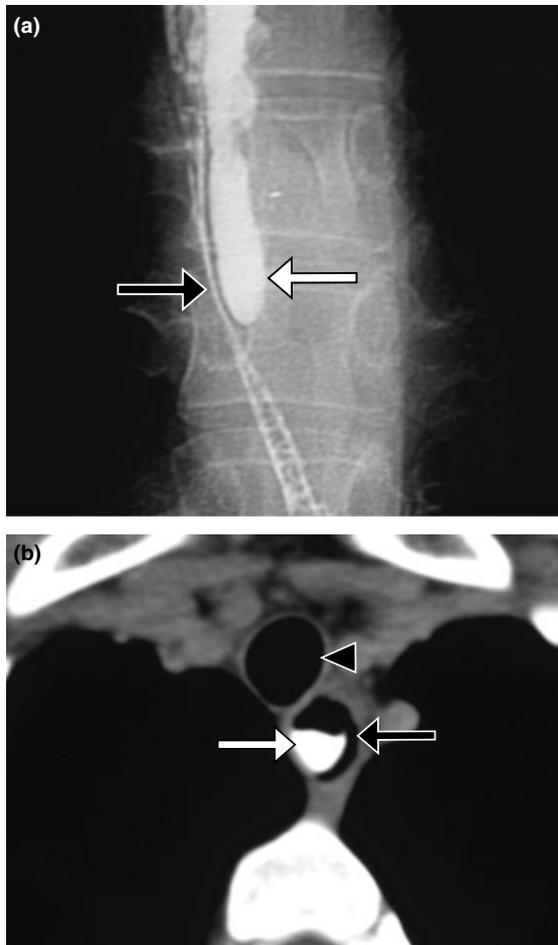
(a) Oesophagography from a 35-year-old female patient, suffering from dysphagia for 15 years. This radiograph was performed immediately after an attempt to remove an impacted food bolus by rigid oesophagoscopy and shows a long dissection of the oesophageal wall. Laceration, dissection and perforation are well known complications of the inflammation-induced remodeling of the oesophageal mucosa. White arrow: oesophageal lumen; Black arrow: dissection channel. (b) CT scan from the same patient, performed after an attempt to remove an impacted food bolus showing a dissection of the oesophageal wall. White arrow: oesophageal lumen; Black arrow: dissection channel; White arrowhead: trachea.
